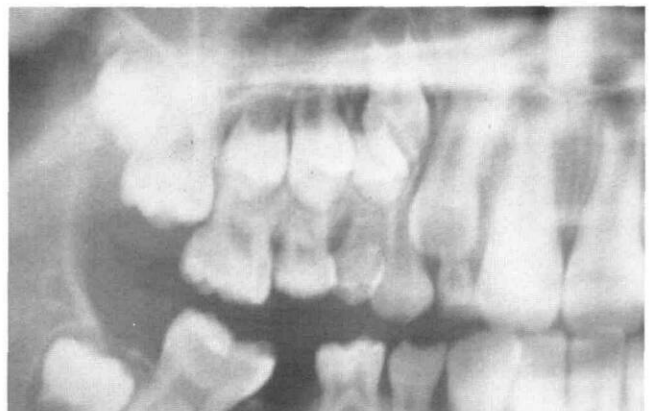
Radiograph showing maxillary right first supernumerary primary molar and supernumerary premolars.
